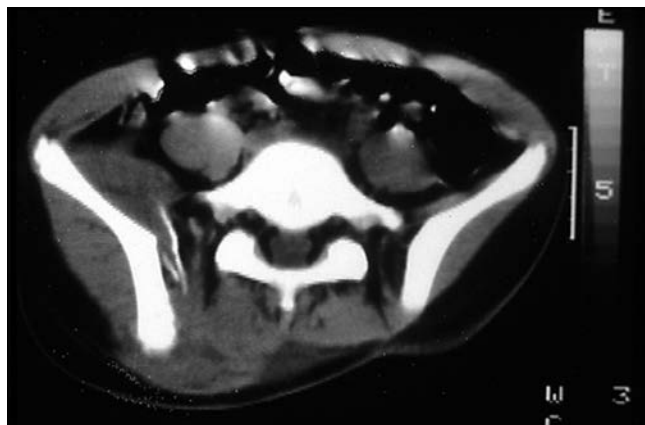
CT is an excellent addition to radiographs for evaluation of pelvic fractures.
